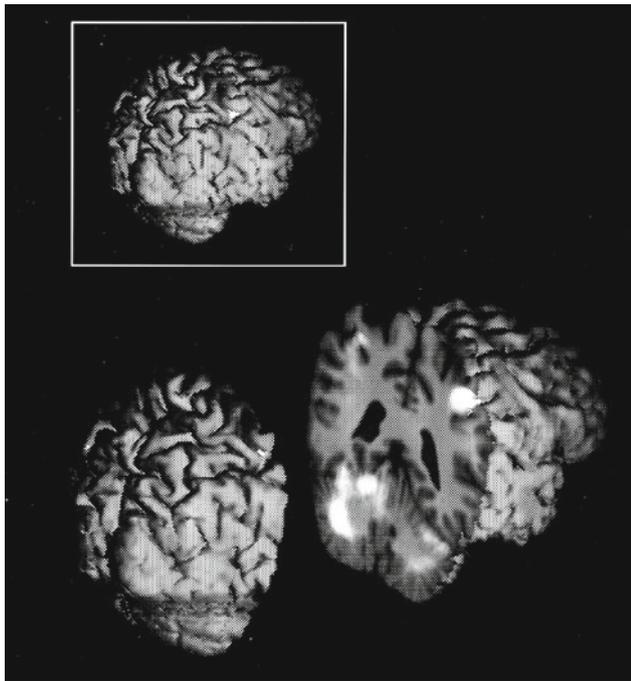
A positron emission tomography (PET) scan is overlaid on an MR image. At the upper left is a three dimensional MRI of the brain viewed from above and to the right. At the bottom the image has been sliced through the motor strip and cerebellum, and the two pieces are separated. The PET image has been overlaid on the slice. The positron emitter is ^{15}O -labeled water. The subject is sequentially touching each finger of the left hand with the thumb. Activity can be seen in the right cerebral sensorimotor cortex (slice, upper right) and in the left cerebellum (slice, lower left). (Image courtesy of Prof. Kelly Rehm, University of Minnesota and the PET Imaging Service, Veterans Administration Medical Center, Minneapolis)
